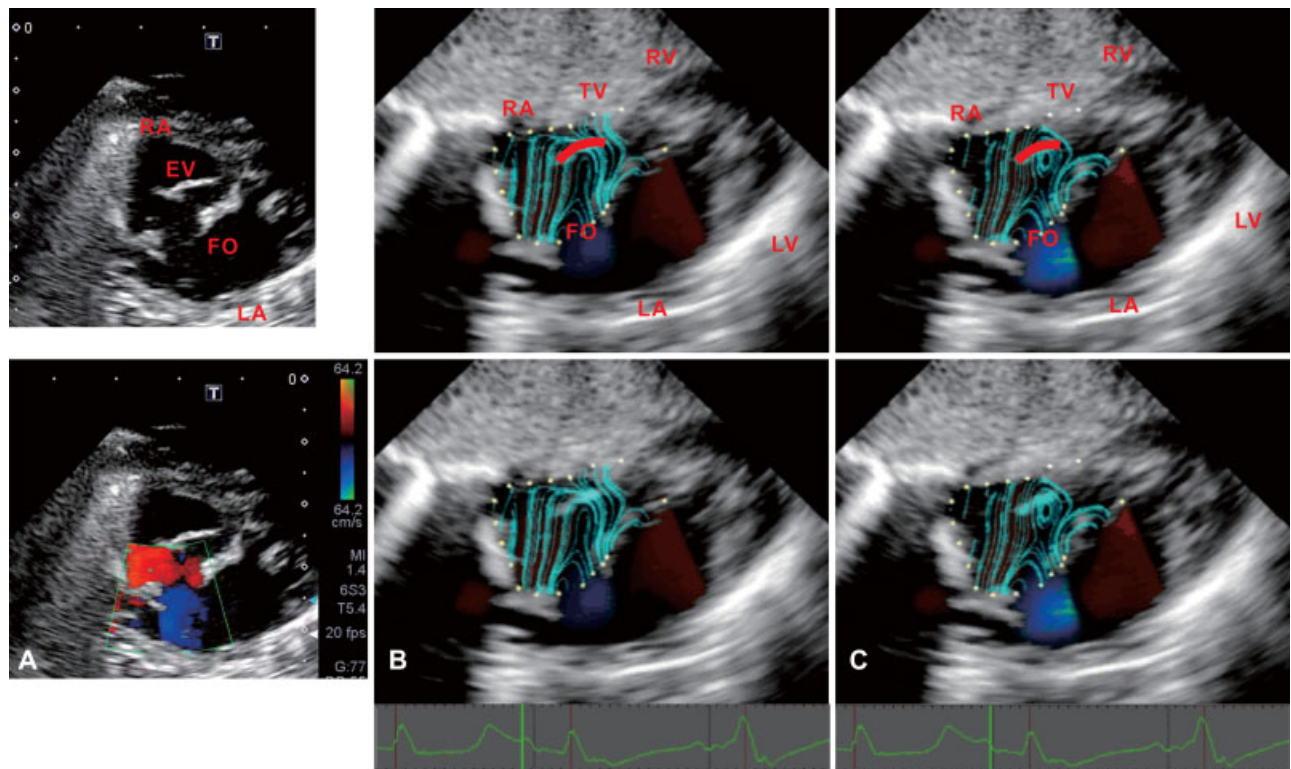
Eustachian valve and right-to-left shunt via the foramen ovale at postnatal day 10. Each image was obtained from the subxiphoid view. (A) Two-dimensional and color Doppler's show the spatial relationship between the tricuspid valve, Eustachian valve, and foramen ovale. (B, C) Streamline on diastolic filling phase by vector flow mapping⁹ with a region of interest on the right atrium. Upper panel added explanations to lower panel images. Red curved lines show a Eustachian valve. These show that vortices in front of the Eustachian valve seems to direct blood from the inferior vena cava to the foramen ovale. EV, Eustachian valve; FO, foramen ovale; LA, left atrium; LV, left ventricle; RA, right atrium; RV, right ventricle; TV, tricuspid valve.
